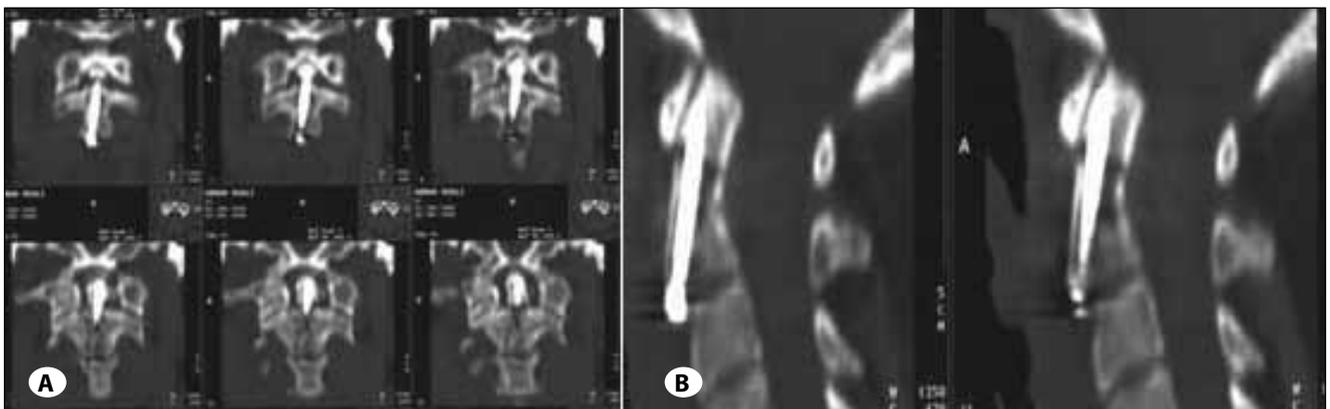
Postoperative cervical spine A) coronal and B) sagittal CT images showing odontoid fracture fixed with a screw.
